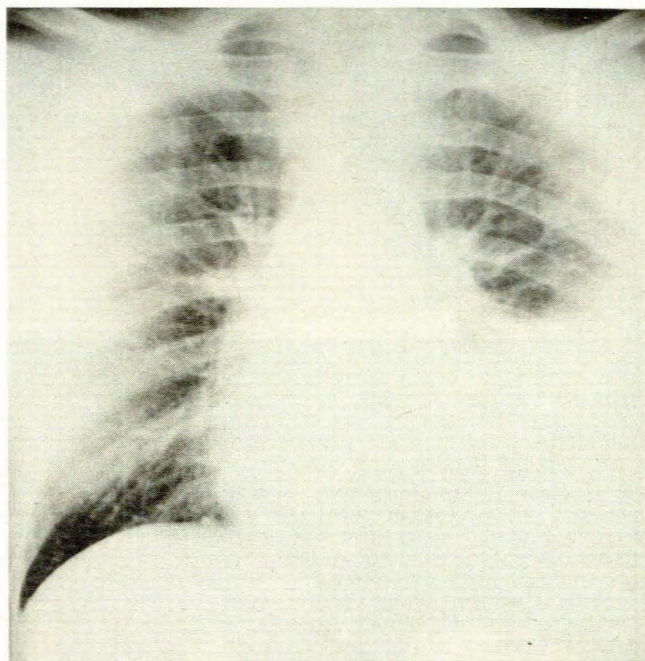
Case 6. Pre-radiography clinical diagnosis: renal calculus, pancreatitis or inflammation in right iliac fossa. No specific diagnosis offered on the radiographs. Operation: long section of gangrenous colon and small intestine in hernia. The patient died postoperatively. Top: radiograph shows nonspecific opacification at left base. Bottom: parallel lucent streaks coming down from the hernia, probably due to gas in mesenteric veins.
